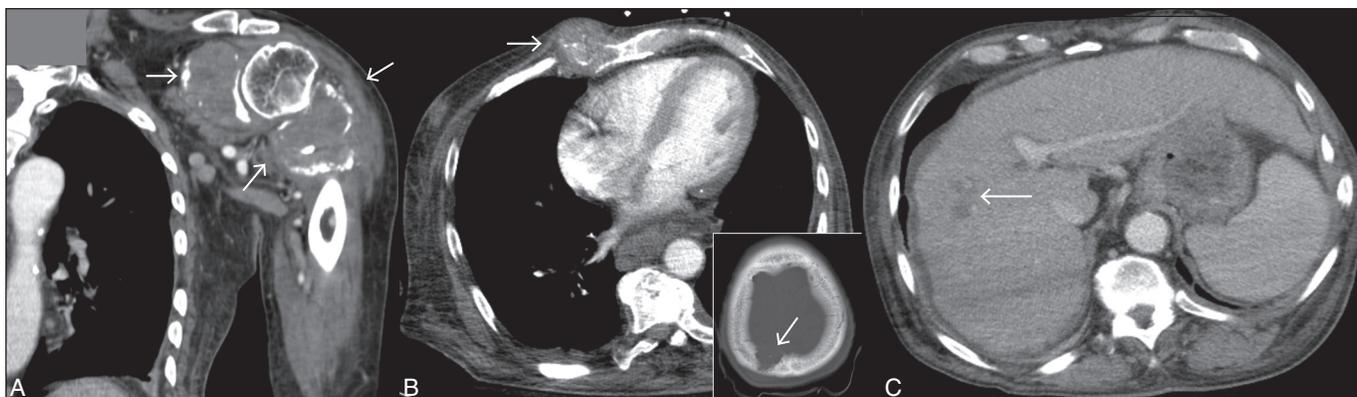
(A) Shoulder CT showing a 9.1 × 5.6 × 5.5 cm destructive expansile lesion at the proximal humeral metaphysis with pathologic fracture and extraosseous soft tissue extension (arrows). (B) Chest CT showing 3.2 × 2.4 × 2.4 cm heterogeneously enhancing soft tissue mass with associated osseous destruction of the fifth right rib at the costochondral junction (arrow). A 2 × 2 cm lytic lesion of the high parietal calvarium near the vertex was identified on head CT (inset, arrow). (C) Abdominal CT showed cirrhotic liver with portal hypertension, moderate perihepatic free fluid, and multiple ill-defined hepatic parenchymal hypodensities abutting the gallbladder fossa (arrow).
